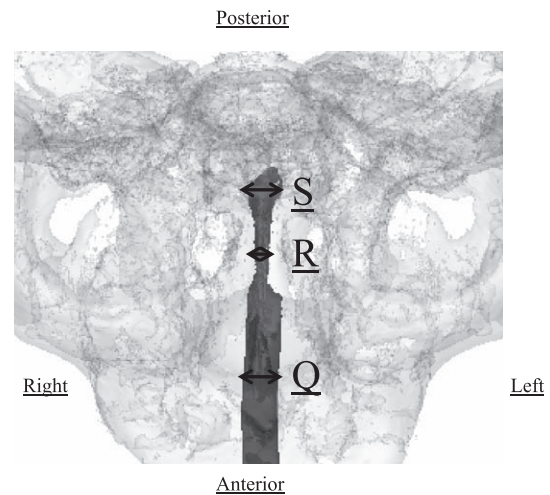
Width measurement items established by CBCT in the horizontal plane. Vomer width was measured by defining 3 items in the horizontal plane (Fig. 3-2). Item Q: anterior-vomer width (width of the most anterior region of the vomer) ; item R: narrow-area width (width of the narrowest region of the vomer) ; and item S: posterior width (width of the alisphenoid).
